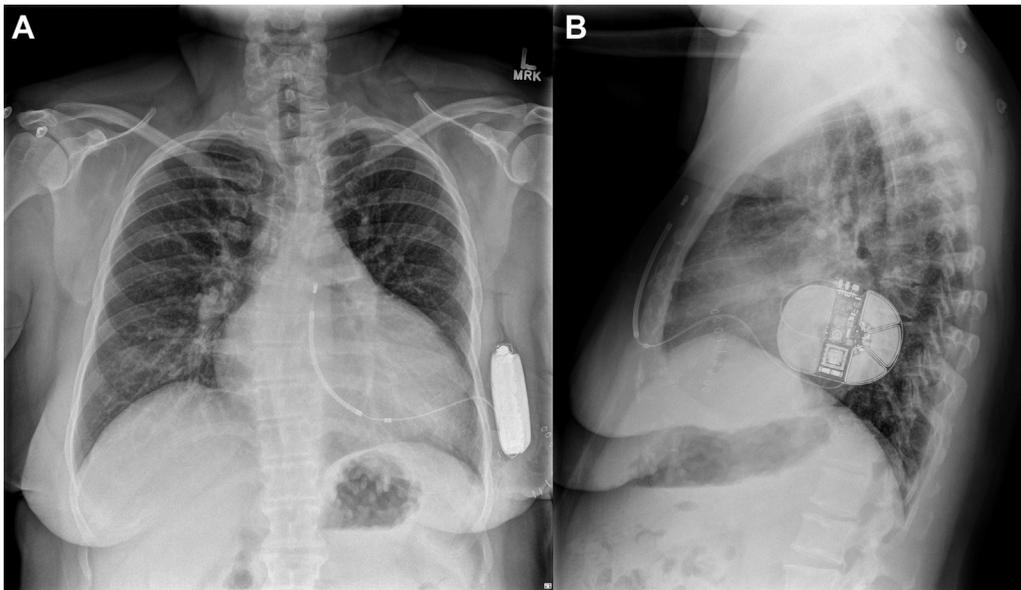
Posterior-anterior (A) and lateral (B) chest radiographs demonstrating appropriate positioning of the subcutaneous implantable cardioverter-defibrillator generator along the midaxillary line following reimplantation of the device.
